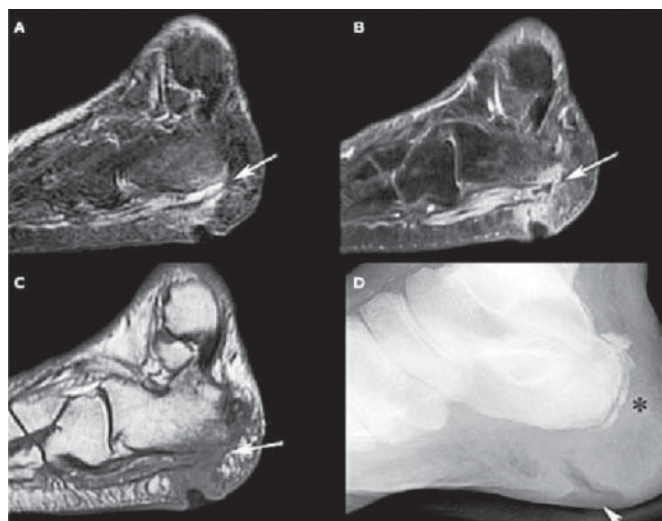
(A) Sagittal fluid-sensitive short-tau inversion recovery (STIR) image demonstrates high signal fluid collection along the plantar surface of the calcaneus (white arrow); (B) Sagittal postcontrast T1-weighted image with fat saturation demonstrates the peripherally enhancing fluid collection (white arrow); (C) Sagittal T1-weighted precontrast image demonstrates some cortical interruption (white arrow); (D) Lateral radiograph demonstrates soft tissue loss overlying the plantar aspect of the calcaneus (white arrow). Osseous remodeling and periosteal reaction about the posterior calcaneus (asterisk) reflect changes associated with longstanding chronic osteomyelitis. (Adapted from Horwich, 2010)²¹
